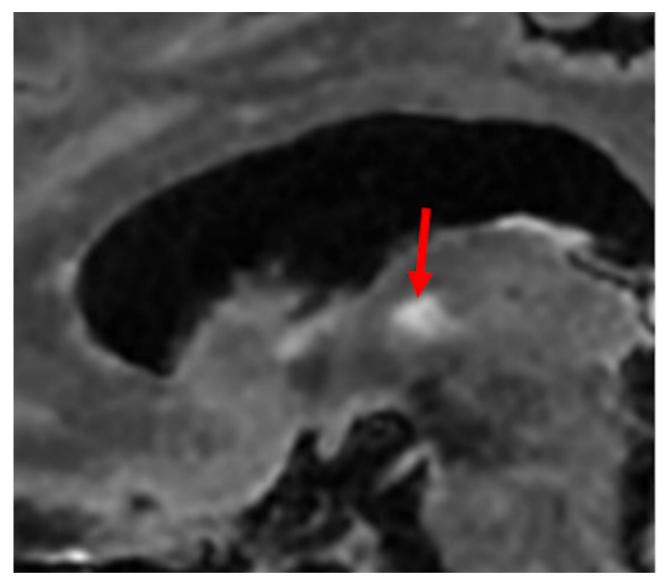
The patient's MRI conducted in October 2023, one month after the stroke. Detail of sagittal section shows the lesion in the left anterior thalamus
